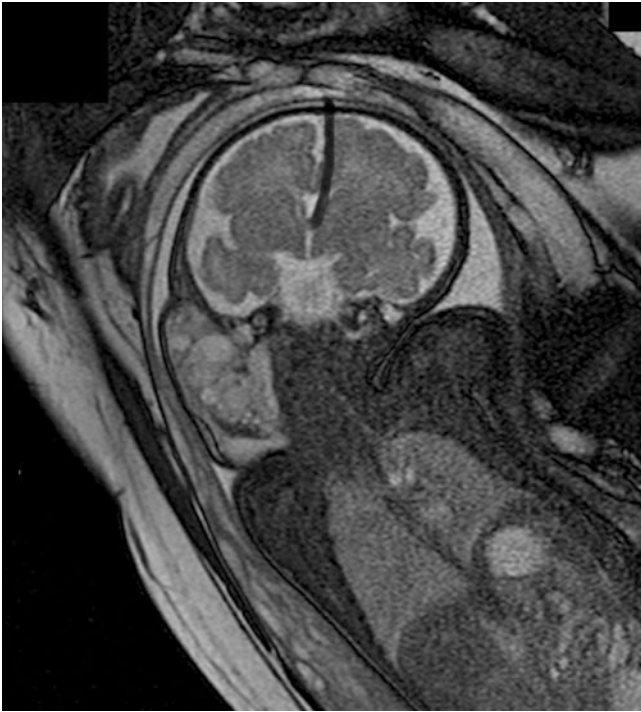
Right-sided cervical lymphatic malformation in a 34-week-gestation fetus. Coronal T2-weighted image from a fetal MR study shows the multiloculated lesion on the right side of the fetal neck
